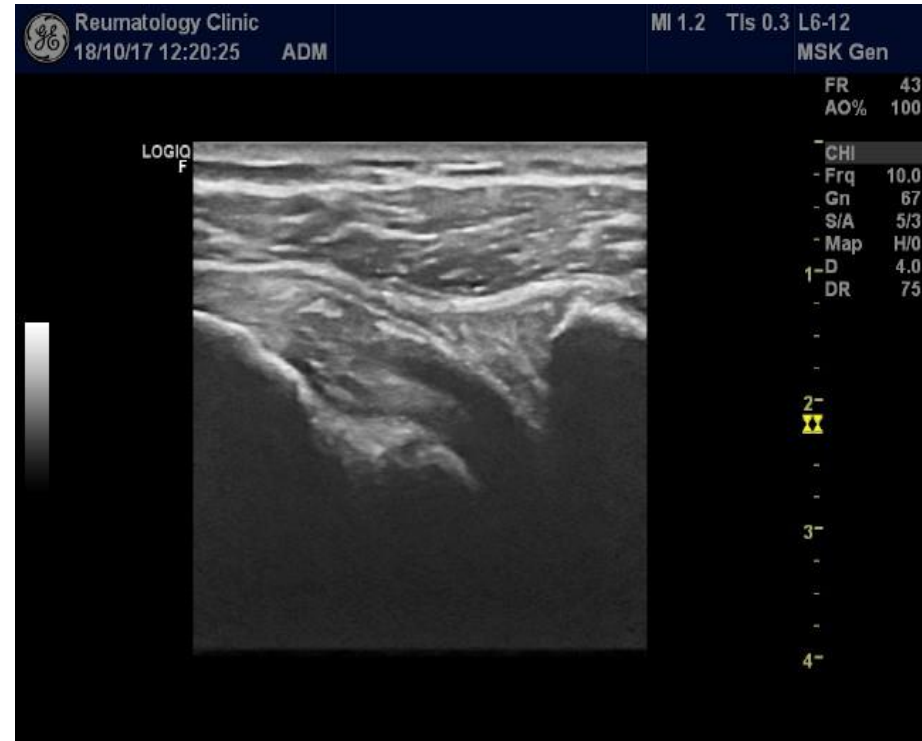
Ultrasound appearance of calcific tendinopathy. (a) Arc morphology: echogenic arc of calcification with deep acoustic shadowing. (b) Nodular morphology: single echogenic focus of calcification without acoustic shadowing. (c) and (d) Fragmented morphology: two or more echogenic foci of calcification with (image (c)) or without (image (d)) acoustic shadowing.
